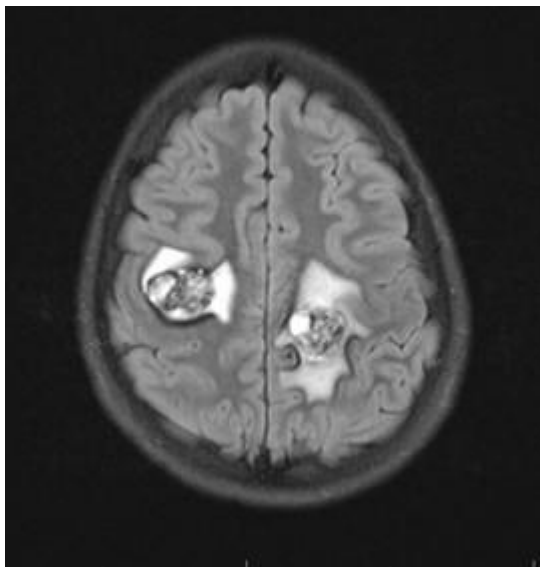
Pre-operative brain MRI T2 image
